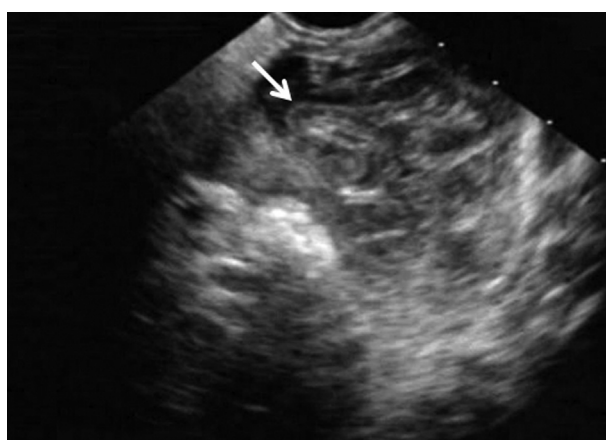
EUS image showing a cystic lesion containing numerous serpentine linear structures manifesting as sonographic water-lily sign (*white arrow*).
